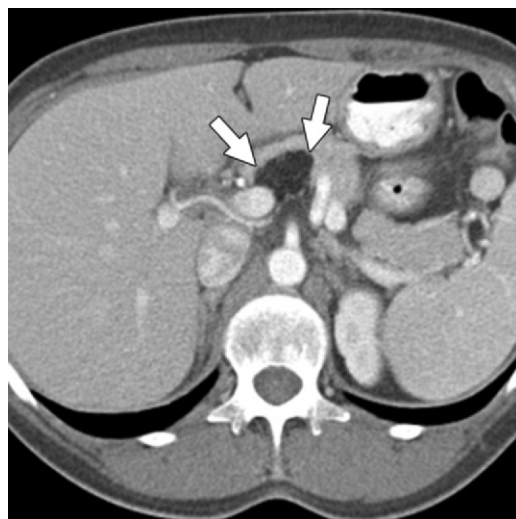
Pancreatic lipoma in a 62-year-old woman. Axial contrast-enhanced CT image shows a well-circumscribed homogeneous fat-attenuating mass (arrows) in the pancreatic body.
